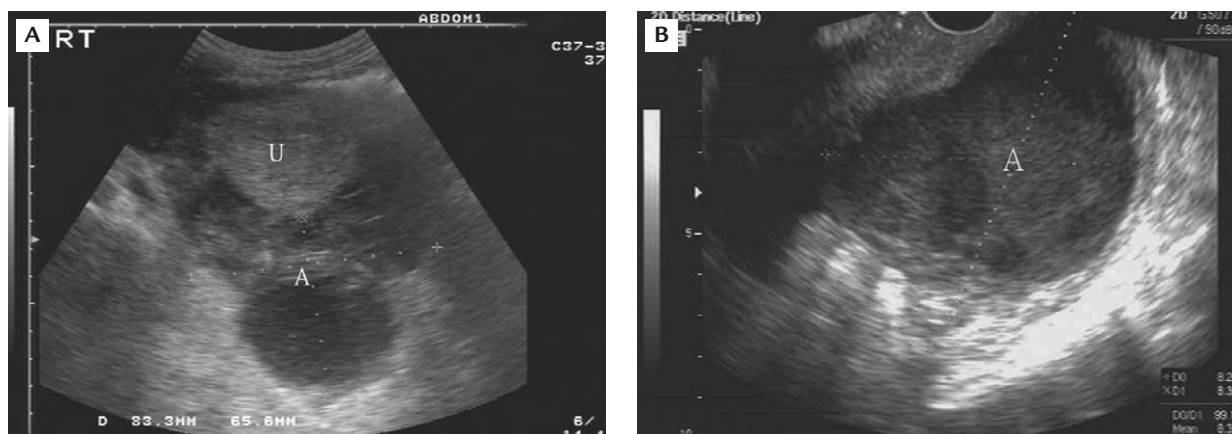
(A) Transabdominal ultrasonography shows right adnexal abscess (8.3 × 6.5 cm). (B) Transvaginal ultrasonography shows left adnexal abscess (8.3 × 8.29 cm). A = abscess; U = uterus.
